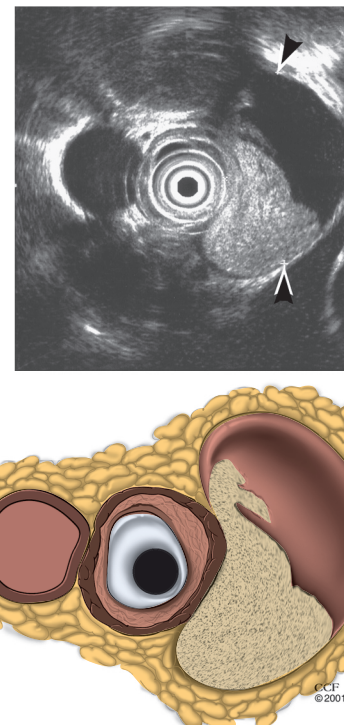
■ Foregut cyst. *Top*: Esophageal ultrasound demonstrates a mass (arrowheads) adjacent to the trachea and esophagus. The cyst has two components, one hyperechoic (white) representing proteinaceous material and one hypoechoic (black) representing fluid. *Bottom*: Foregut cyst in close proximity to esophagus and trachea.
